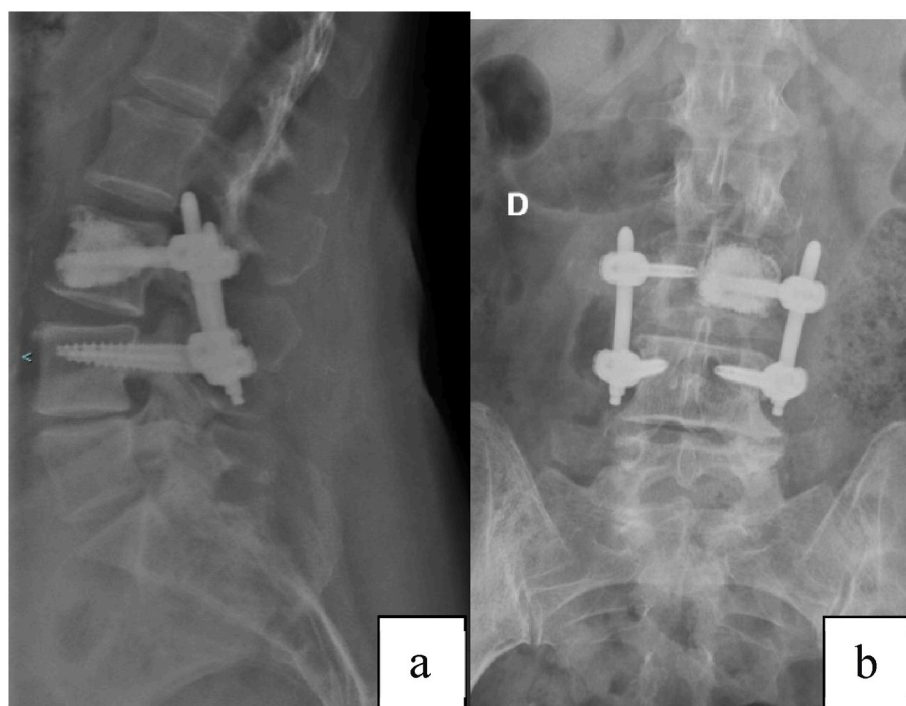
a, b: Post-operative X-rays.
